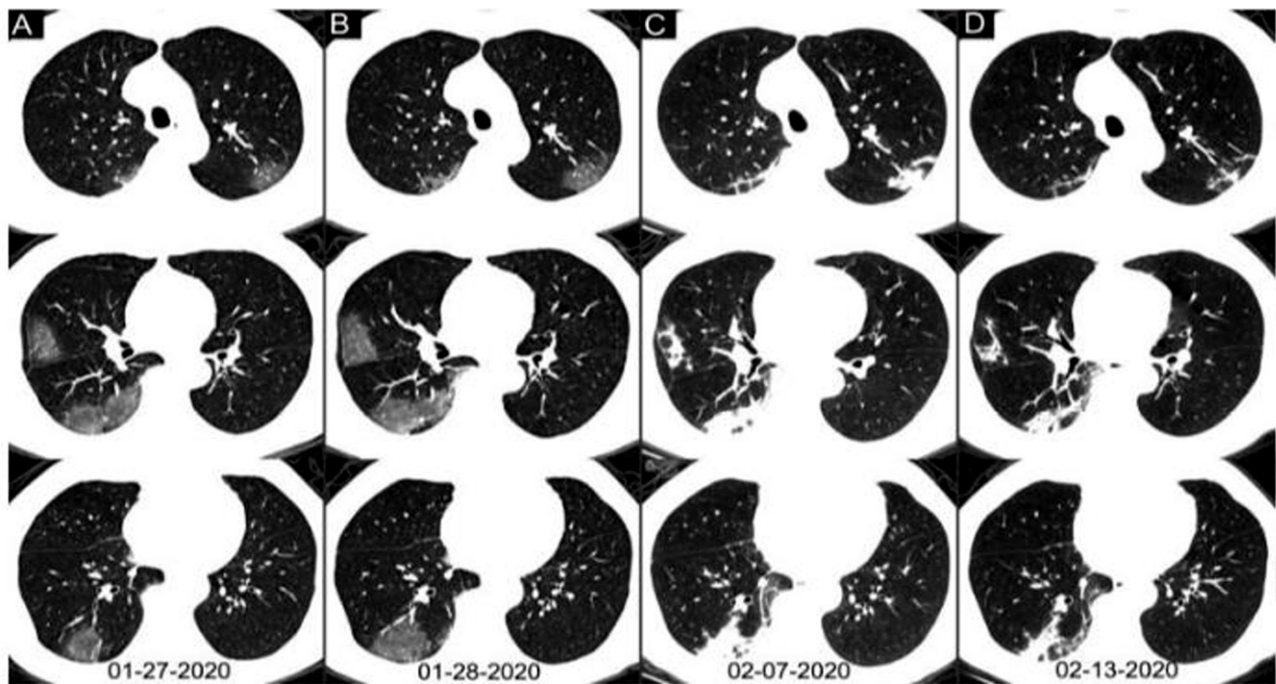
CT Serial changes⁷
